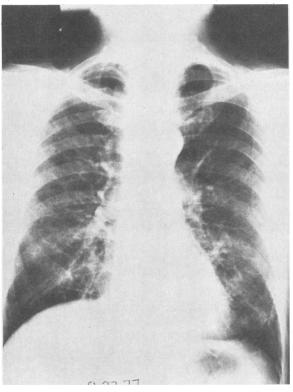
X-ray film of the chest taken ten days after discharge showing complete clearing of the infiltrate.
